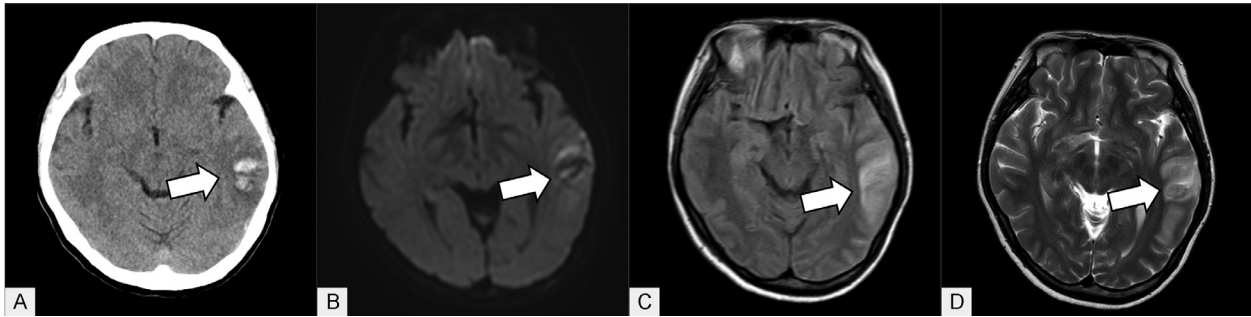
Hemorrhagic infarction on the day of onset. Computed tomography revealed patchy high attenuation with surrounding edema in the left temporal lobe (A), which showed high signal with low signal internally (B). On fluid-attenuated inversion recovery imaging, the area around the hemorrhage exhibited high signal intensity (C), whereas on T2* imaging, it ranged from low to high signal intensity.
